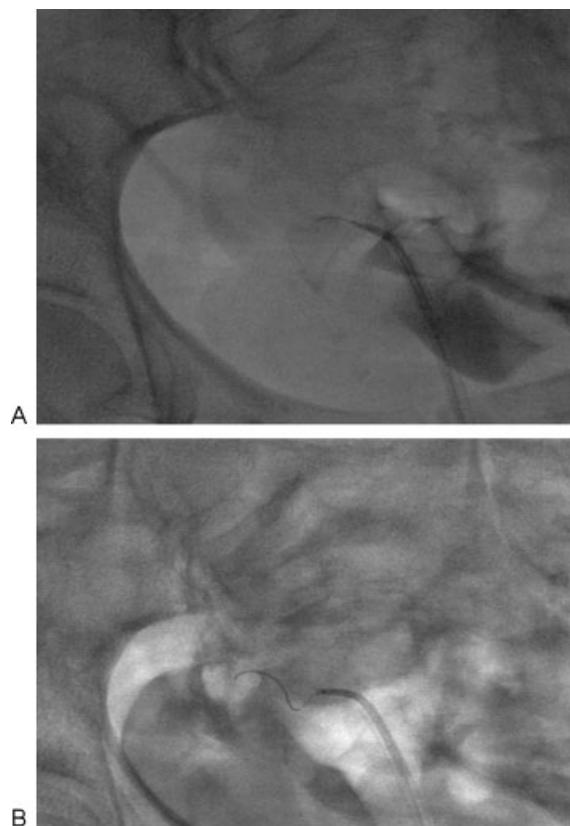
(A) Selective catheterization of the right fallopian tube is performed with a microcatheter system through the 5F cornual catheter. (B) Radiograph demonstrates recanalization of the right fallopian tube using a microwire.
